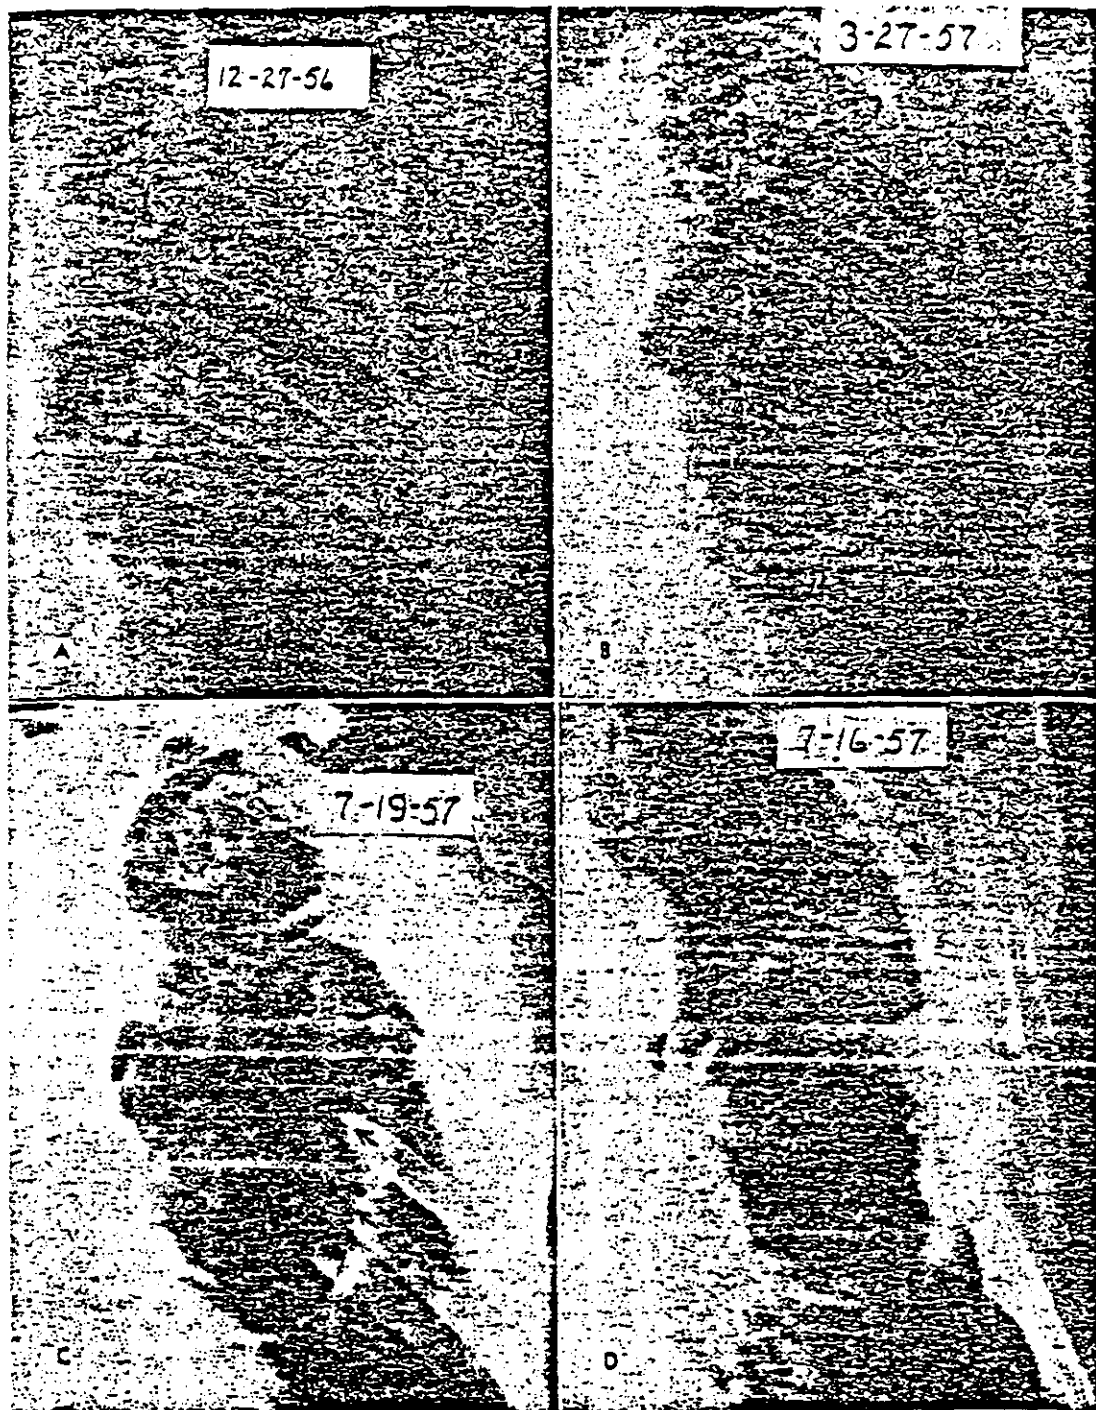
(A) Carcinoma of the left lung in a seventy-one year old white man who had been a coal miner for forty years. He had been in his usual health except for increasing shortness of breath and chronic cough until November, 1956, when he developed pain in the left side of the chest and hemoptysis. A roentgen examination on December 27, 1956 showed a large cavity in the upper portion of his lower lobe. It was thought to be tuberculosis and anthracosis. Note that the ribs are not involved. (B) Roentgenogram made in March, 1957. The appearance was essentially the same except that this time the sixth rib was eroded. (C) Roentgenogram made in July, 1957. The cavity was larger and portions of four ribs were destroyed. We thought the lesion was a carcinoma which had largely excavated itself. A biopsy confirmed the diagnosis. (D) A slightly oblique roentgenogram shows the wall of the lesion adjacent to the thoracic wall (arrows).
